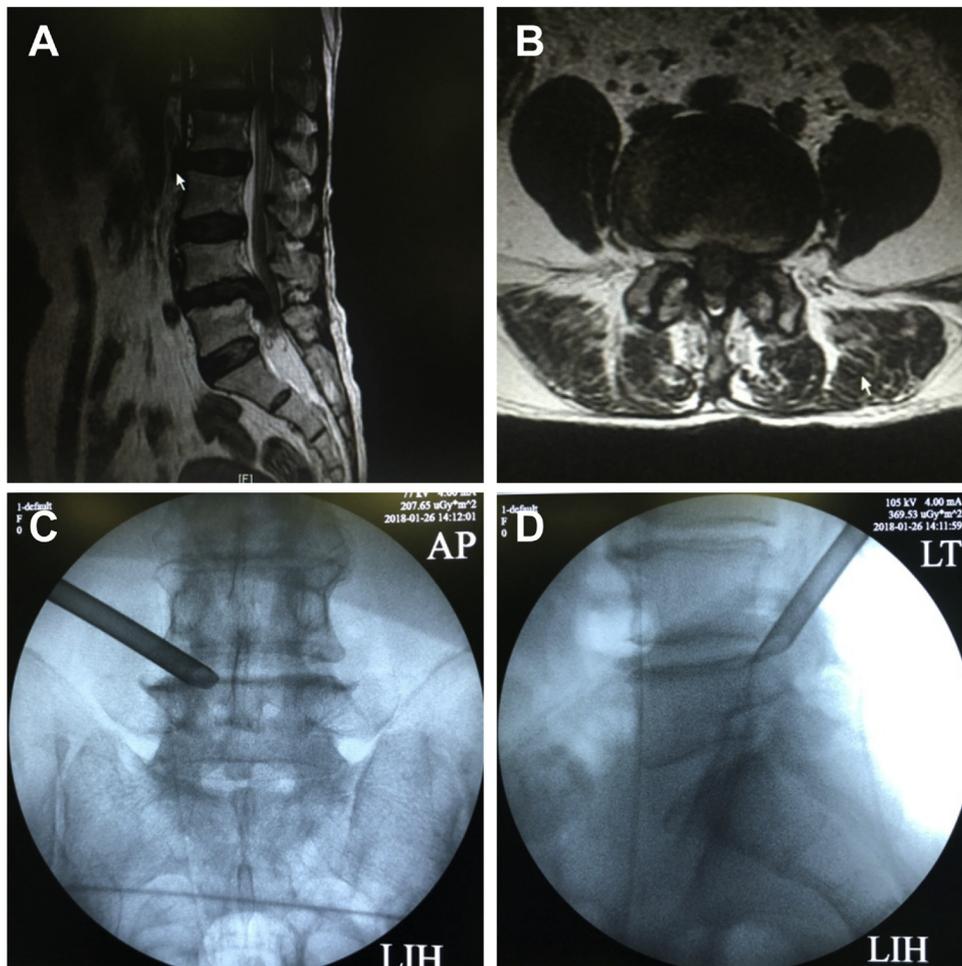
Sagittal (A) and axial (B) MRI scan of a 58-year-old male with massive lumbar disc herniation. Anteroposterior (C) and lateral (D) fluoroscopic view of transforaminal approach to the L4-5 disc level during disc decompression.
